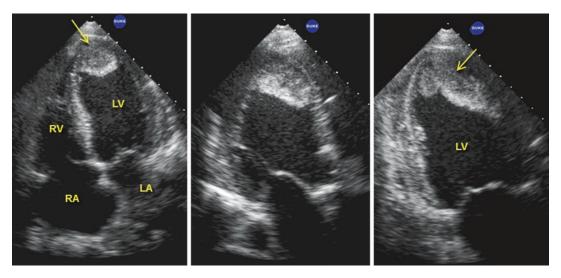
Apical four (left panel), three (middle panel) and two-chamber (right panel) views in a patient post anterior myocardial infarction. The apical thrombus is
